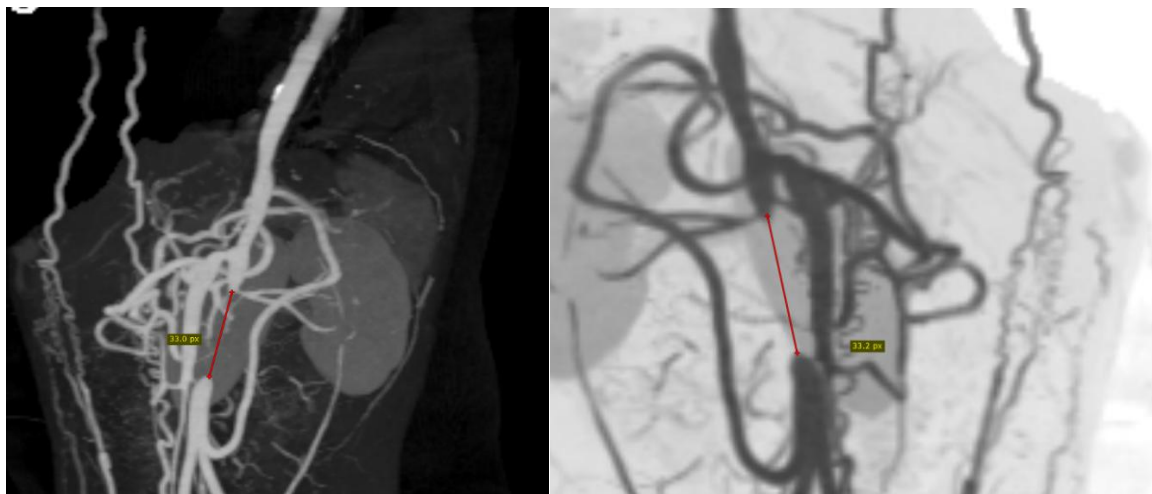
Reformatted images of CTA showing stenosed aortic segment in sagittal and oblique planes
